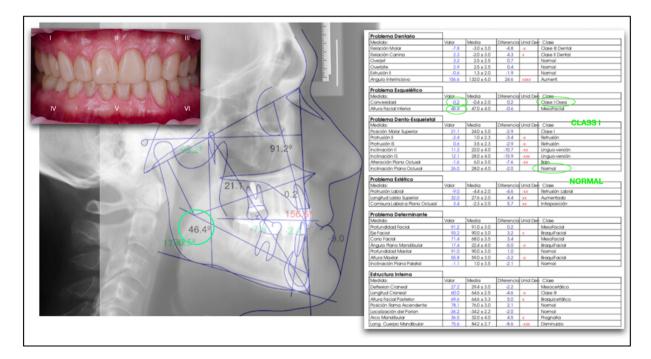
Lateral tele-radiography with Ricketts cephalometric analysis after temporization.
